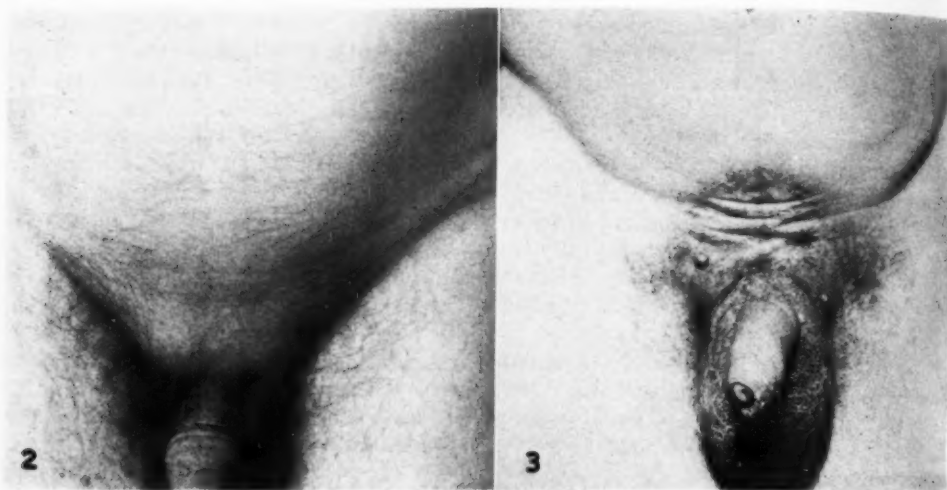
Large multiple papillary carcinoma of bladder (Grade II), treated in 1941. Tumor dose through three fields, 4,300 r in fifty-nine days. Combined incident and exit dose to anterior field 5,200 r. Skin soft with central epilation. Posterior skin normal in appearance. Patient well, without urinary symptoms, in 1948. Reproduced from *Supervoltage Roentgen Therapy* (1).
